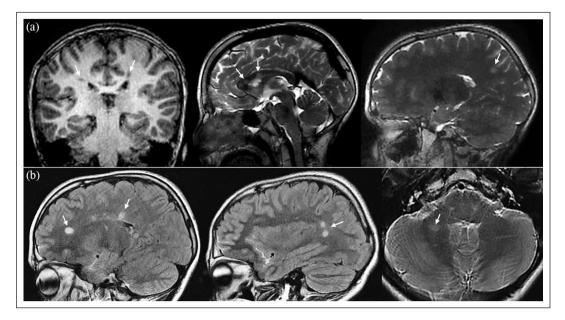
MR images at baseline and follow-up. (a) One coronal T_1 -weighted and two sagittal T_2 -weighted MR images from the brain imaging protocol of the Generation R Study, belonging to the 11-year-old identified male RIS case. The coronal image shows periventricular T_1 -hypointense white matter lesions in both the right and left parietal lobe. The sagittal T_2 -weighted images demonstrate additional intracallosal and subcortical T_2 -hyperintense white matter lesions. (b) Sagittal T_2 -weighted fluid-attenuated inversion recovery (FLAIR) and axial T_2 -weighted MR images of the same patient at follow-up brain imaging (22 months later). The T_2 FLAIR sagittal images show hyperintense lesions in the periventricular white matter of the supratentorial brain. These white matter lesions were new in comparison with the previous baseline MR examination. The axial T_2 -weighted image shows the infratentorial hyperintense white matter lesion in the right cerebellar hemisphere.
